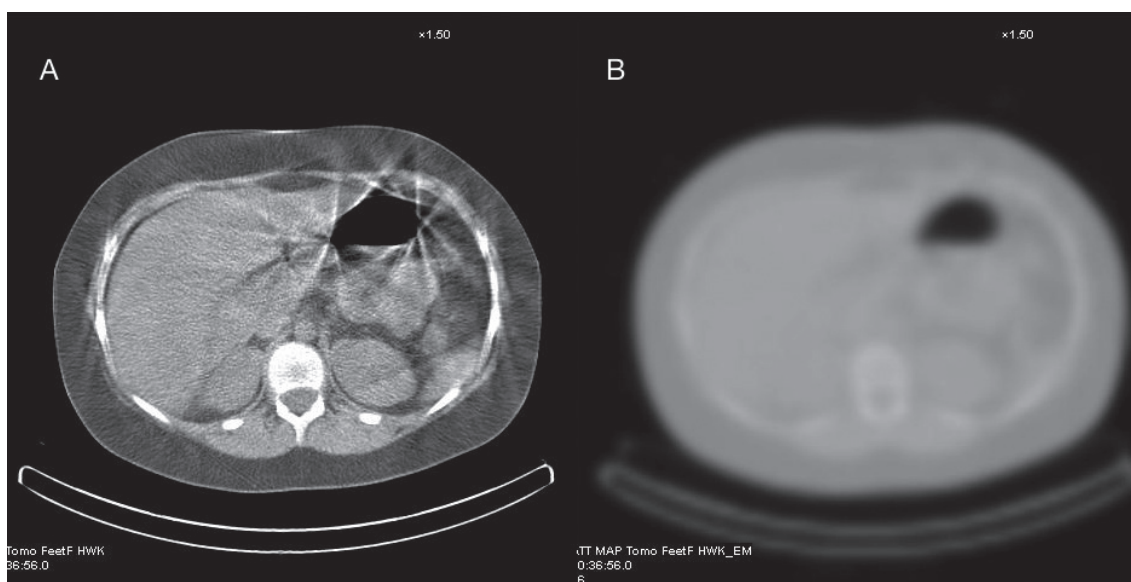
(A) Transaxial CT data from a slow rotation CT scan of the abdomen and (B) data are smoothed for AC and loses the streak artefacts.
